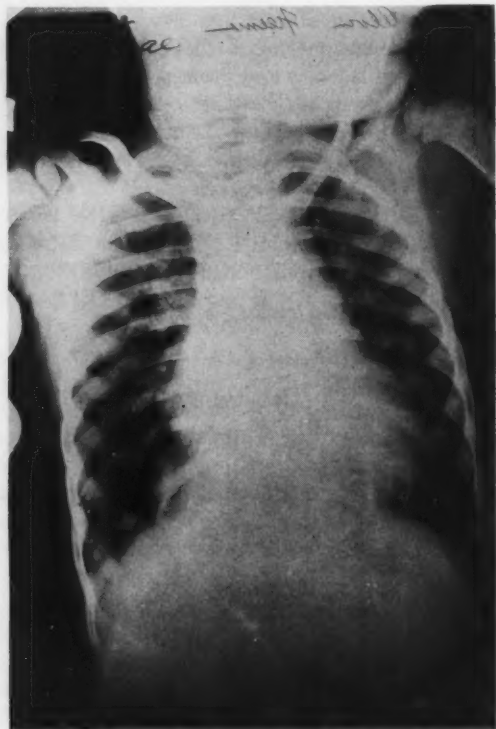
X-ray of the chest.
